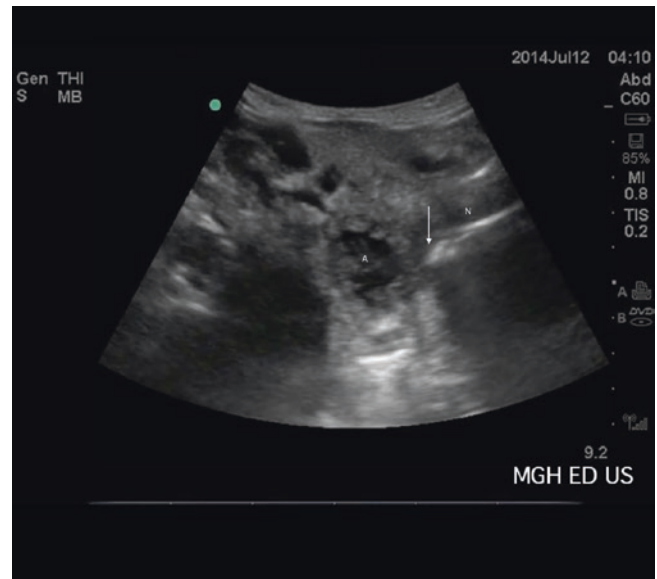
This telescopic submandibular image demonstrates ultrasound-guided needle aspiration of a peritonsillar abscess (A). A longitudinal view of the entire needle (N) can be seen using this method. The arrow points to the needle tip. Image courtesy of Andrew Liteplo
